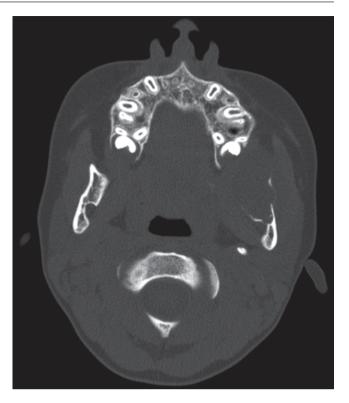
Axial computed tomography (CT) scan of lesion in left mandibular ramus, with erosion of cortical bone and buccal and lingual expansion
